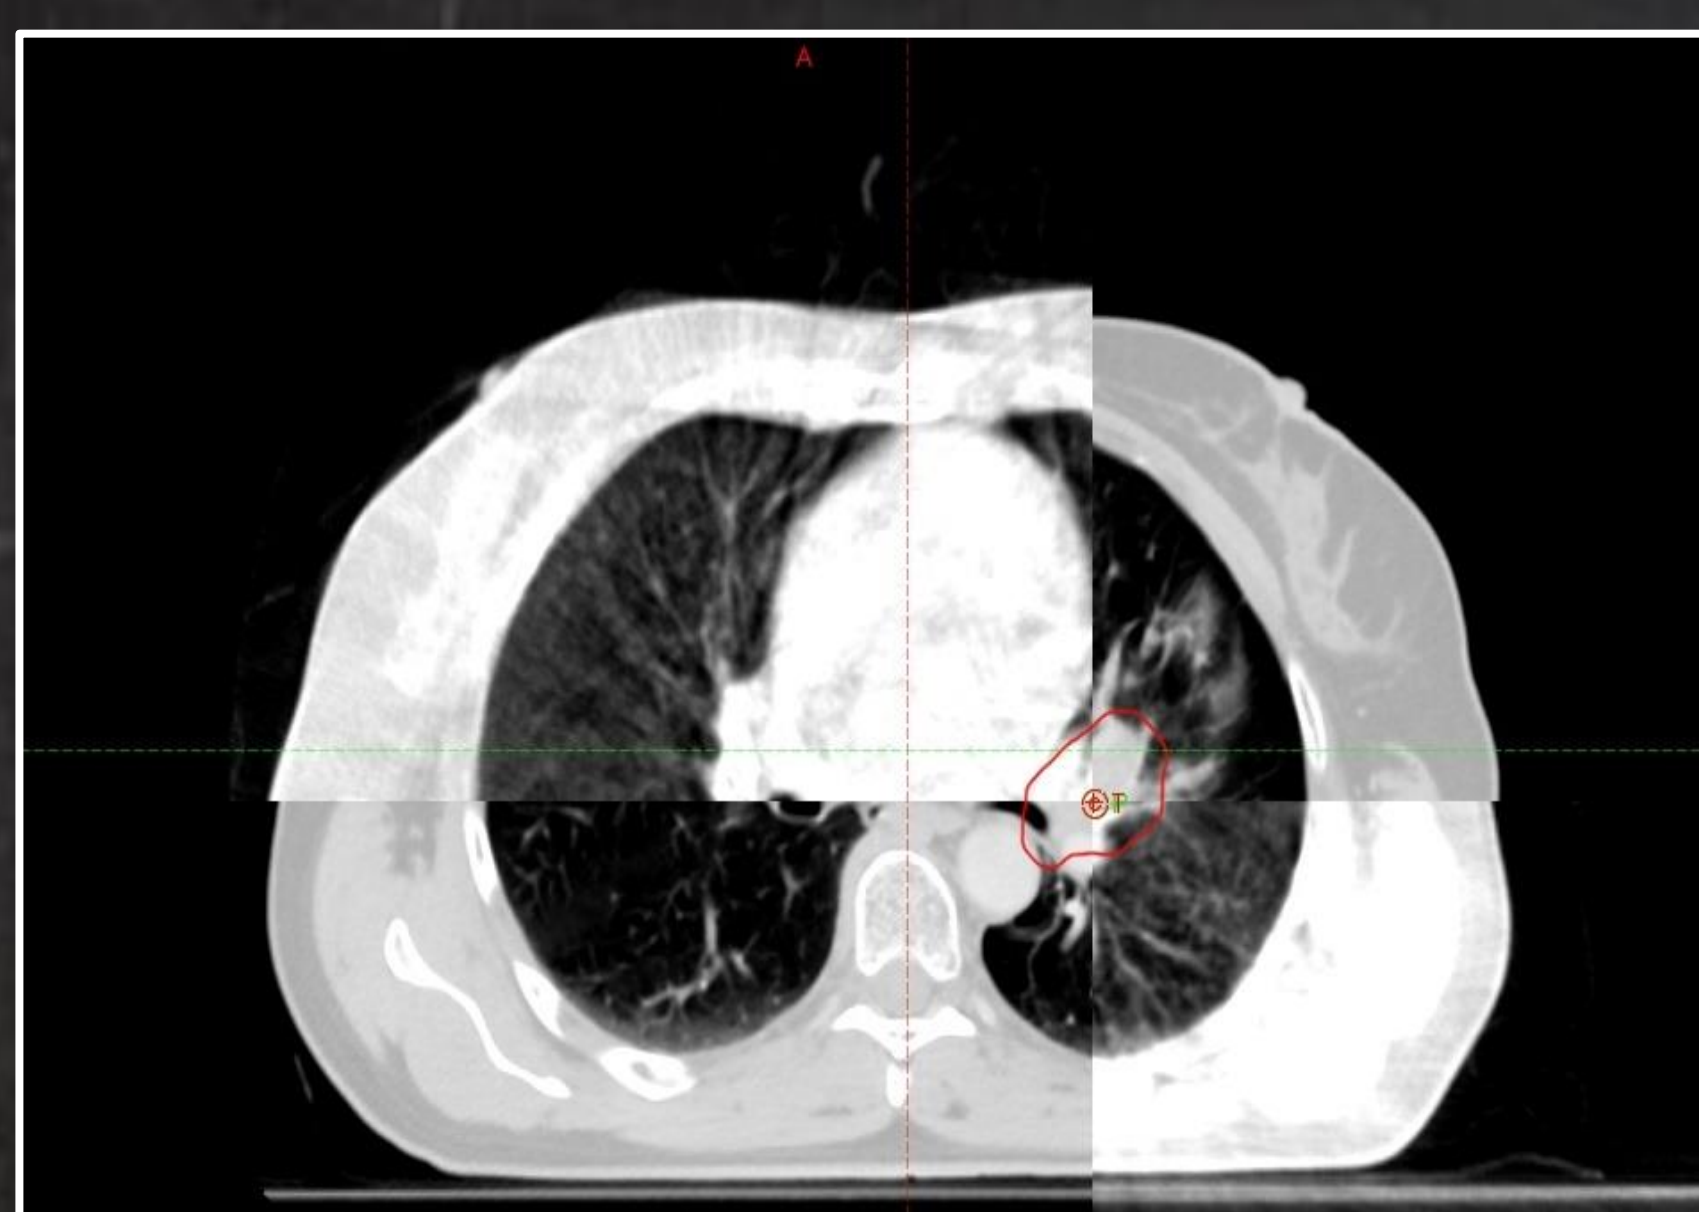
Example of CBCT soft tissue match
